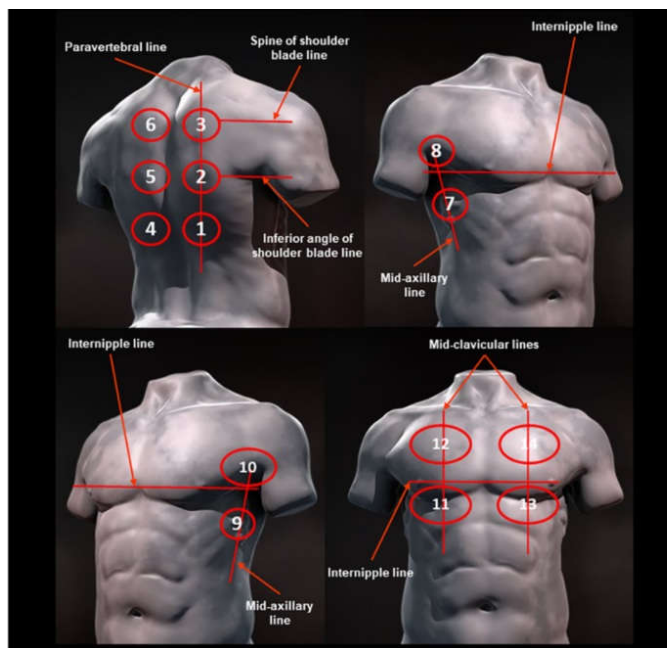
Proposed sequence of lung ultrasound by Soldati *et al.*⁽²⁴⁾
